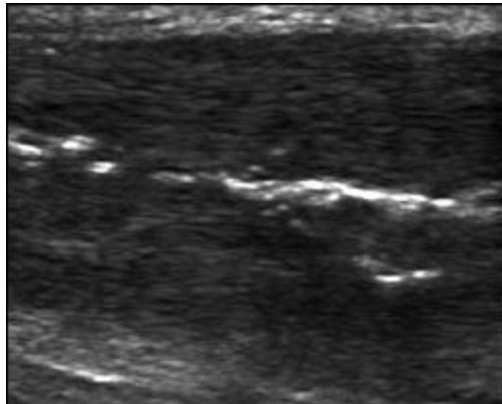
Sonographic image obtained after injection in 82-year-old man with midportion Achilles tendinosis shows hyperechoic dextrose solution dispersing within abnormal tendon
